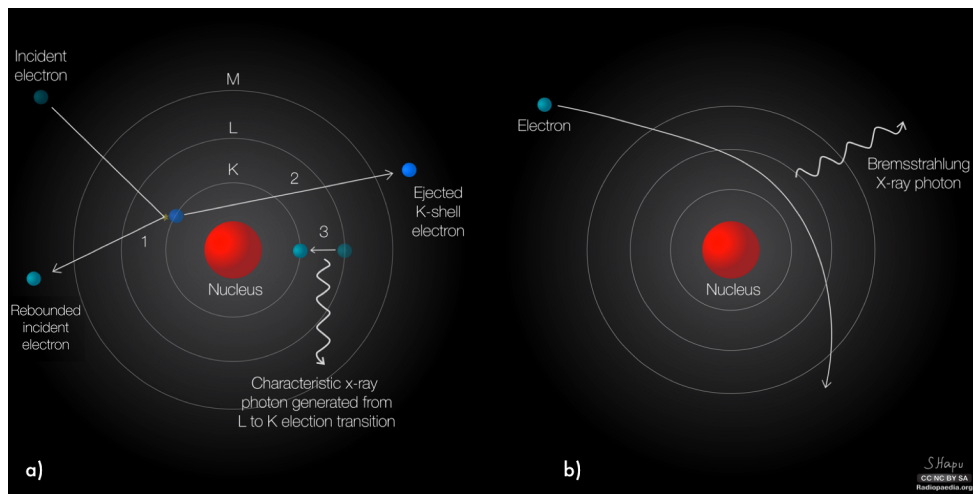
X-ray generation
